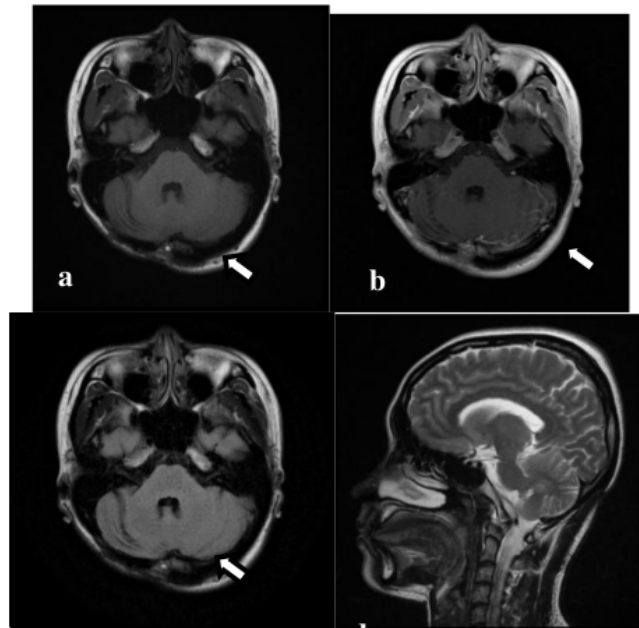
Radiological findings (evaluation), hypointense on T1W1 (a) no contrast enhancement (b), hypointense on T2 FLAIR (c), hyperintense on T2W1, sagittal (d)
